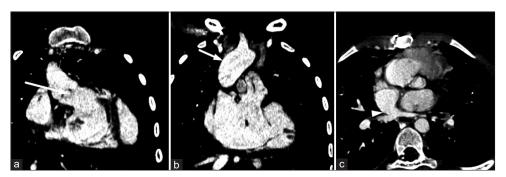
Origin of ascending aorta and total anamalous pulmonary venous connection. (a and b) coronal sections of computed tomography (CT) pulmonary angiogram images showing ascending aorta (arrow) arising from right ventricle, (c) axial sections of CT pulmonary angiogram image showing pulmonary veins from both lungs draining into a common channel (arrowhead) before draining into the right atrium
